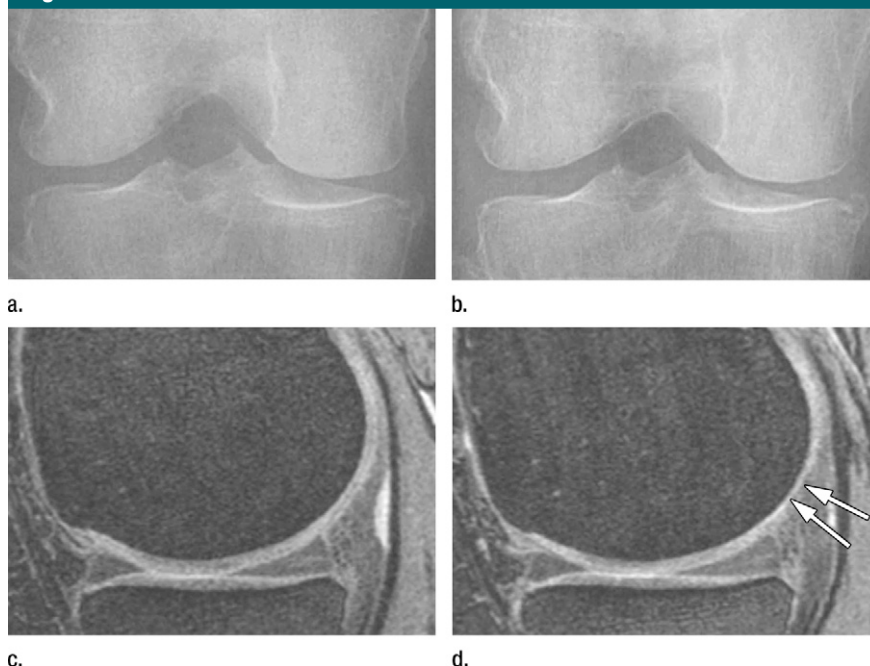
Sensitivity to change. Comparison of baseline and 24-month follow-up imaging examinations. (a, b) Anteroposterior radiographs (a) show no joint space narrowing at baseline but a definite medial tibial osteophyte and (b) no change in JSW at 24 months and slight increase in size of the medial tibial osteophyte. (c, d) Sagittal three-dimensional (3D) dual-echo steady-state (DESS) MR images (repetition time msec/echo time msec, 16.3/4.7; flip angle, 25°) show (c) no cartilage loss in medial tibiofemoral compartment at baseline but (d) definite cartilage damage in posterior medial femur at 24-month follow-up. The damage can only be visualized on MR images due to the posterior location (arrows) of the cartilage abnormality.
